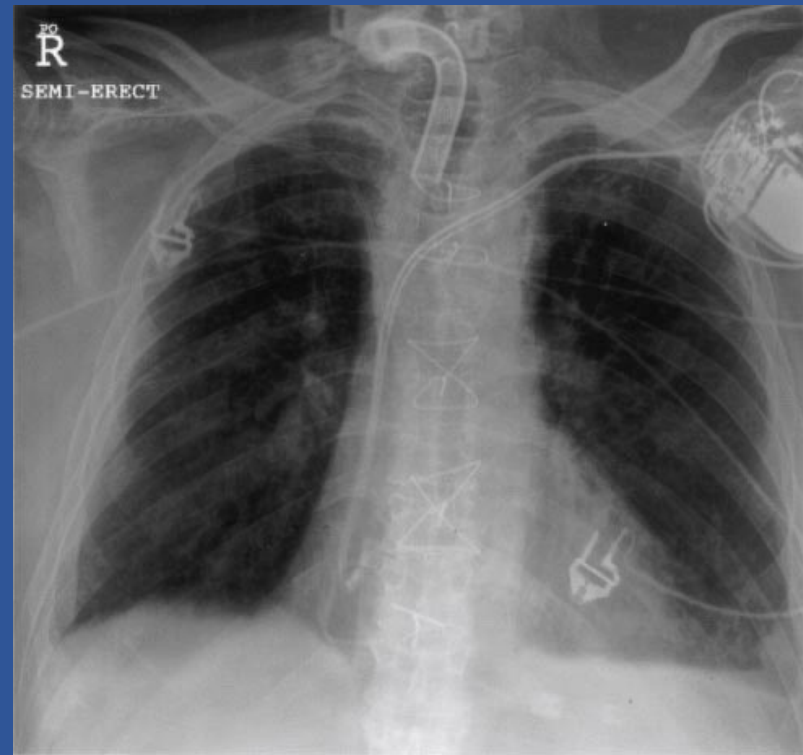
A curved tracheostomy tube in which the distal end abuts the posterior tracheal wall. There is a hint of this on the anterior-posterior chest radiograph (left), and this was confirmed by bronchoscopy (right). Approaches to this problem include replacing the tube with one that is larger, angled, or of extra length.
